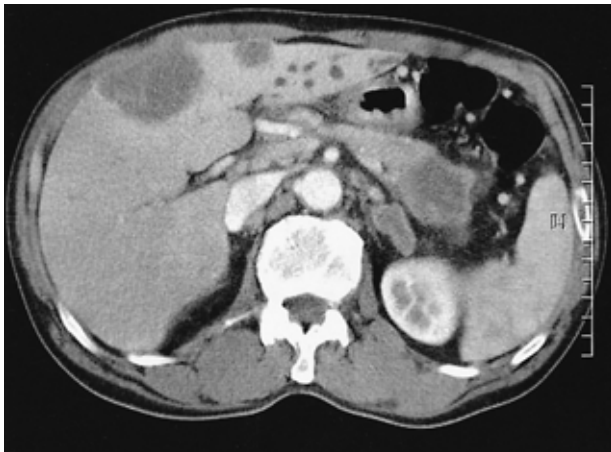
Abdomen computed tomography shows a low density mass in the tail of the pancreas along with multiple liver metastases.
